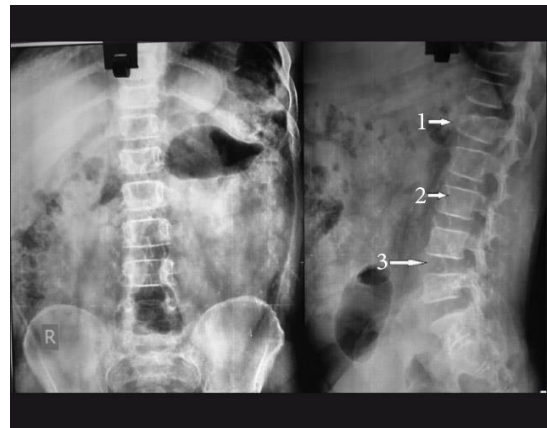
X-ray spine 1. Bullet shaped L1 vertebra. 2. Osteoporosis 3. Increased inter vertebral spaces
